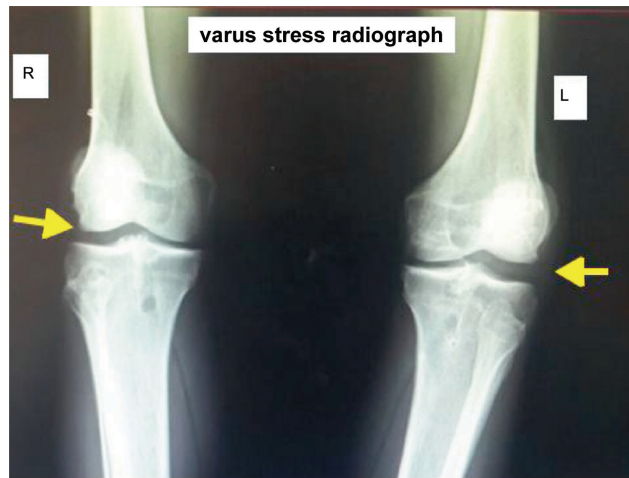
The final bilateral simultaneous varus stress radiograph is showed in this picture. The soft wedge placed between the knees and the Velcro belt at the supramalleolar level produce a varus stress in both knees at the same time, requiring just one radiograph to evaluate side to side difference in the lateral compartment. The yellow arrows show the lateral gapping. R, right; L, left.
